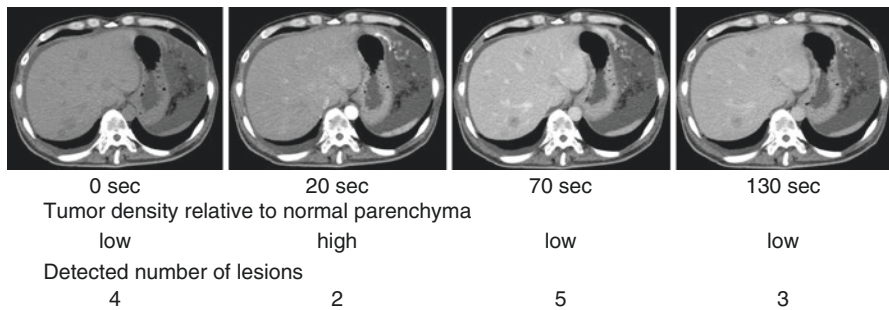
Dynamic contrast-enhanced CT series in a man of 60 years with hepatic metastases of GIST. Visual assessment of tumor density relative to normal parenchyma and the numbers of detected hepatic metastases are presented. Image obtained at 70 s reveals maximal number of lesions compared to other phases. Optimal CT timing is important to assess hepatic metastasis of GIST on dynamic contrast-enhanced CT
